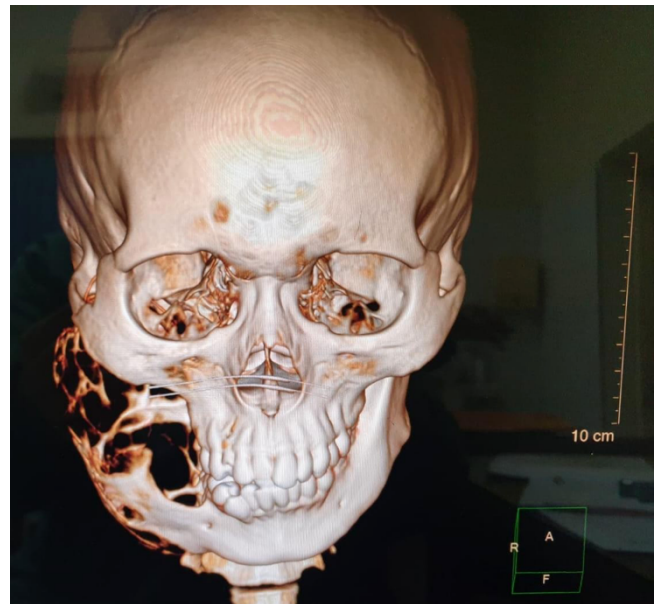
Computed tomography imaging showing a multilocular lesion with typical soap-bubble appearance.
